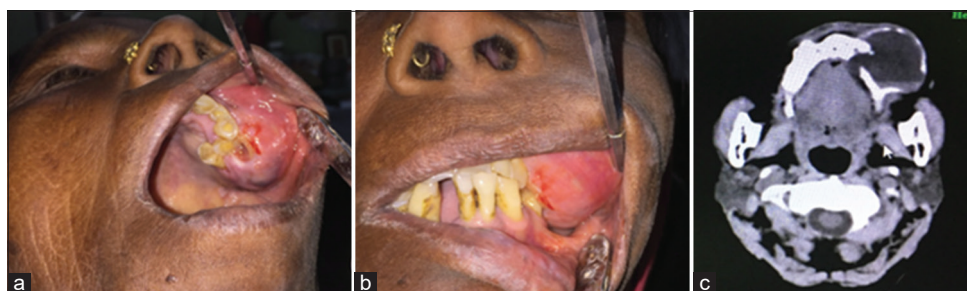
(a) Intraoral presentation of mucocoele, (b) Pathology obstructing occlusion, and (c) Contrast-enhanced computed tomography scan showing expansile homogeneous mass with scalloping and resorption of maxillary antrum walls (Case)
